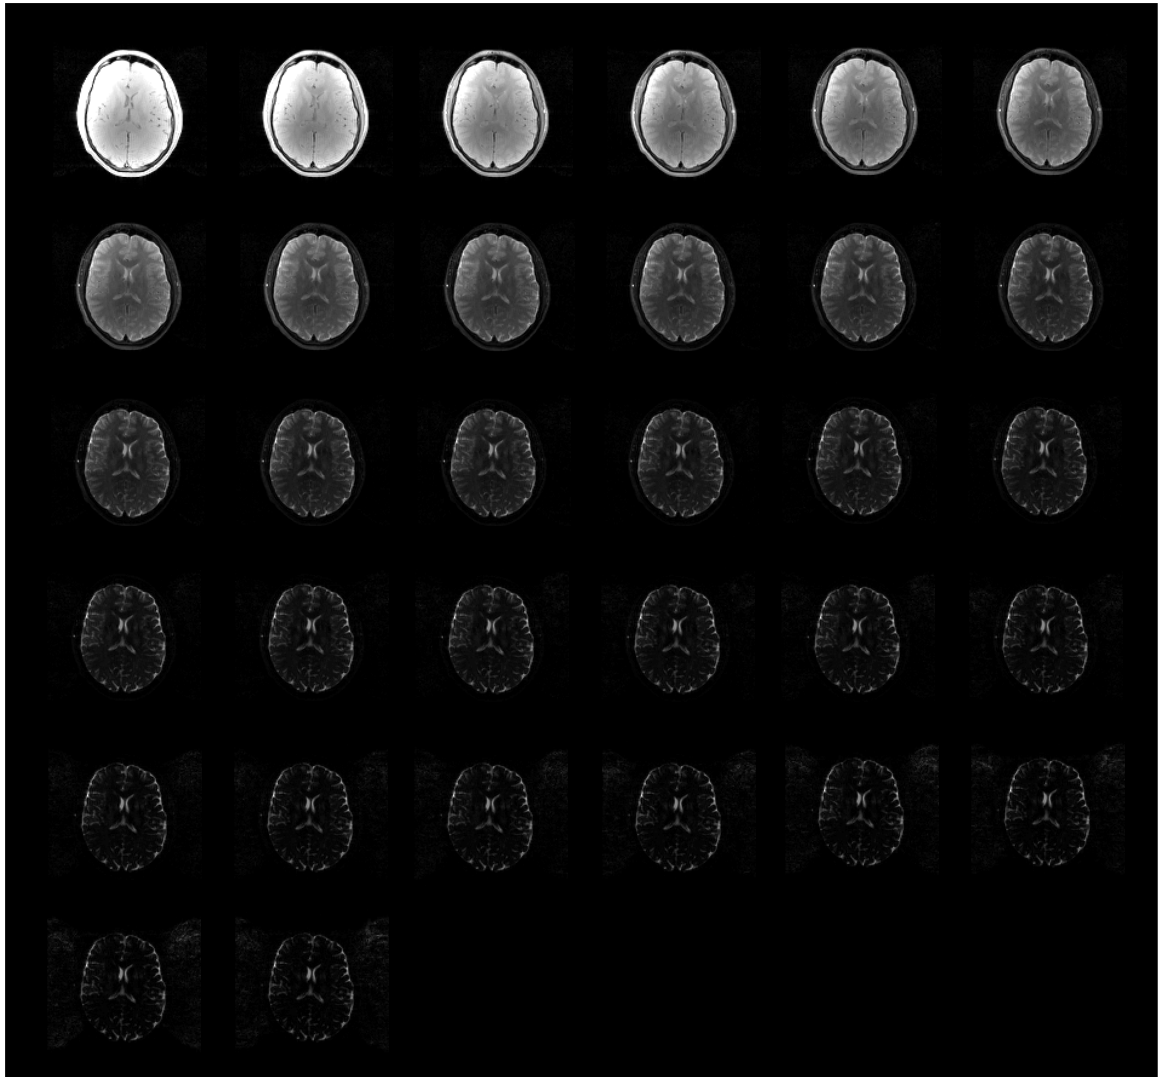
The series of T2-weighted images obtained from the spin-echo acquisition.
